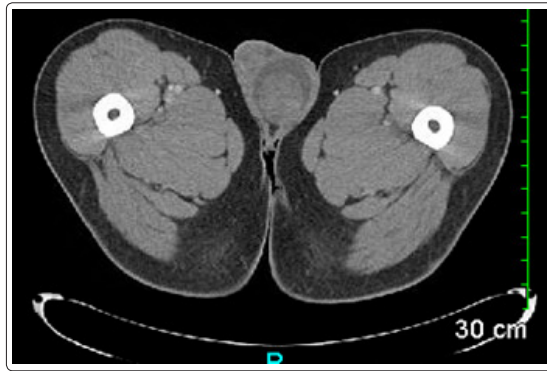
CT of Pelvis/Abdomen without Contrast
